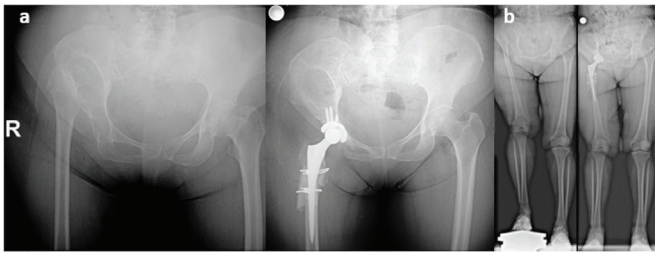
(a) Pre-operative and post-operative pelvis anteroposterior radiograph. (b) Pre-operative and post-operative lower extremity orthoroentgenography
